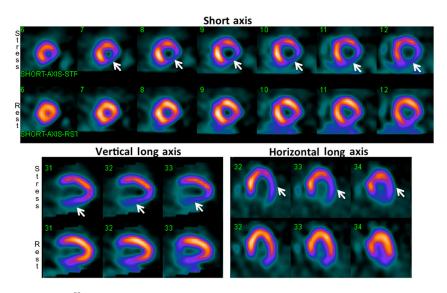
Exercise (Ex) and rest 99mTc-sestamibi SPECT images of a 56-year-old man with long-standing poorly controlled diabetes (poor compliance), hypertension, and diabetic neuropathy and nephropathy with stage 4 chronic kidney disease (serum creatinine 5.6 mg/dL). The patient underwent pharmacological stress-rest MPI as a part of cardiac evaluation prior to being listed for renal transplant. He had poor Ex capacity, but denied any symptoms of chest pain. He was on aspirin, metoprolol, atorvastatin, and insulin. He received 0.4 mg of regadenoson i.v. over 10s. His heart rate changed from 90 to 102 beats per minute and BP from 160/100 to 146/80. He developed chest heaviness following regadenoson, which resolved spontaneously over the next 2 min. There was 2 mm down-sloping ST segment depression in the precordial leads, which persisted for more than 3 min into recovery. Stress and corresponding rest perfusion images in short axis (top two rows), vertical and horizontal long axes (rows 3 and 4) show a large area of perfusion abnormality involving the inferior and lateral walls and contiguous anterior wall, which is reversible on rest imaging (arrows). In addition, transient post stress LV dilation is seen (TID ratio 1.20). On gated SPECT imaging, transient hypokinesia of inferior and lateral walls was noticed on poststress images, with normal wall motion on rest imaging. LVEF was 52% on the poststress images and 57% on the rest images. This is a high-risk abnormal study with a large area of ischemia in multiple vascular territories, transit poststress LV dilation, and wall motion abnormalities and warrants coronary angiography. His impaired renal function necessitated institution of dialysis prior to coronary angiography. He underwent coronary angiography after being started on hemodialysis. This showed severe three vessel CAD: LAD had multiple 60-80% narrowing, with 70% narrowing of D1 branch; LCx has 90% proximal narrowing with 70-80% narrowing of OM1 and OM2; and RCA had multiple 80-90% narrowing. He underwent CABG with left internal mammary artery graft to the LAD and SVG to the LCx and PDA branch of the RCA. He was cleared for renal transplant after he recovered from the CABG.
